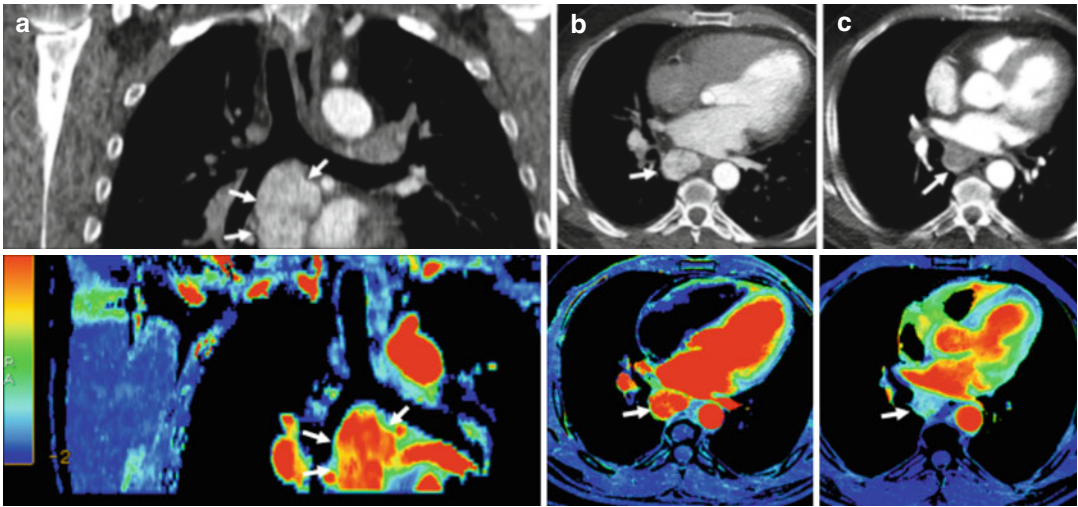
Renal carcinoma with metastatic mediastinal lymph nodes treated with an anti-VEGFR agent. Pretherapy coronal (a) and axial (b) reformatted conventional CT images (*top row*) and perfusion blood volume (BV) parametric maps (*bottom row*) show a conglomerate of hypervascular metastatic nodes in the subcarinal area (arrows). Perfusion BV parametric maps show high BV
